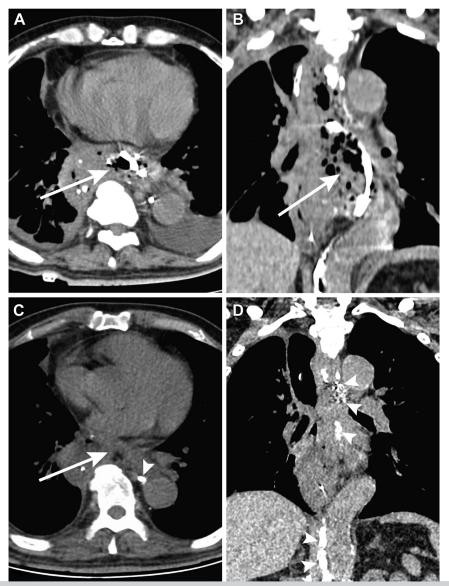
Postoperative axial (A) and coronal (B) computed tomography (CT) scans of the chest 5 days after the procedure showing the cystic lesion had dramatically shrunk (*arrow*) and bubbles of air in the residual collection. Postoperative axial (C) and coronal (D) CT scans of the chest after the drainage catheter had been removed (6 weeks after the procedure) showing complete disappearance of the original cyst (*arrow*) and embolization glue and coils (*arrowheads*) in the thoracic duct.
